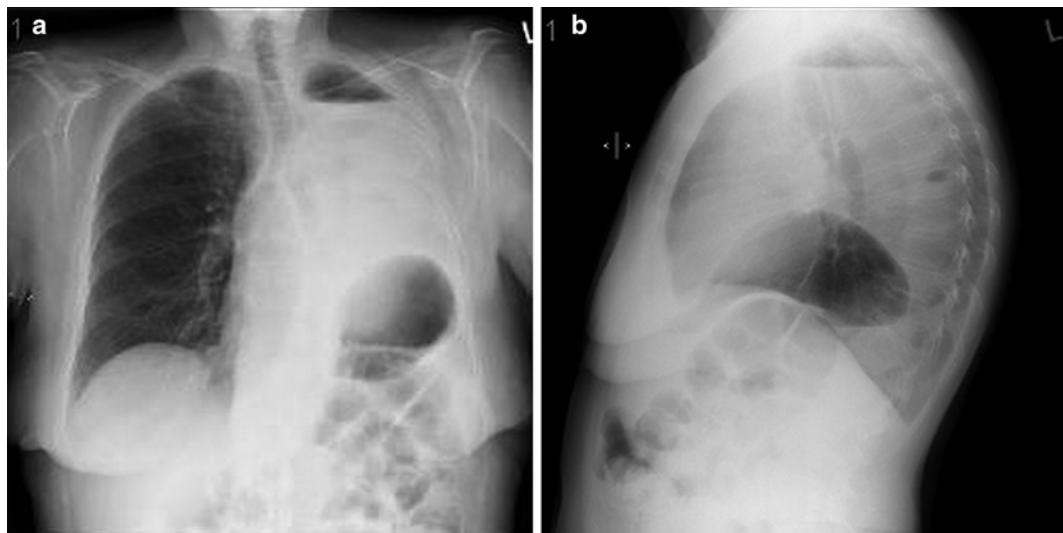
(a, b) A chest radiograph in anterior–posterior and lateral position in a patient after a left-sided pneumonectomy. The opacity in the left lung field is fluid in the hemithorax.
